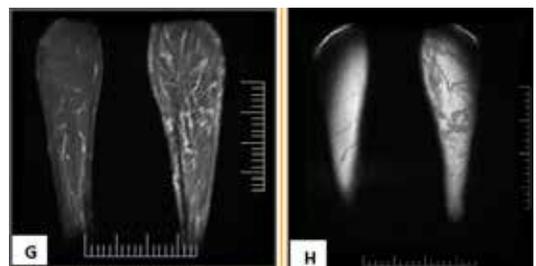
Fig G&H: MRI SHOWING DILATED SUB CUTANEOUS VEINS
